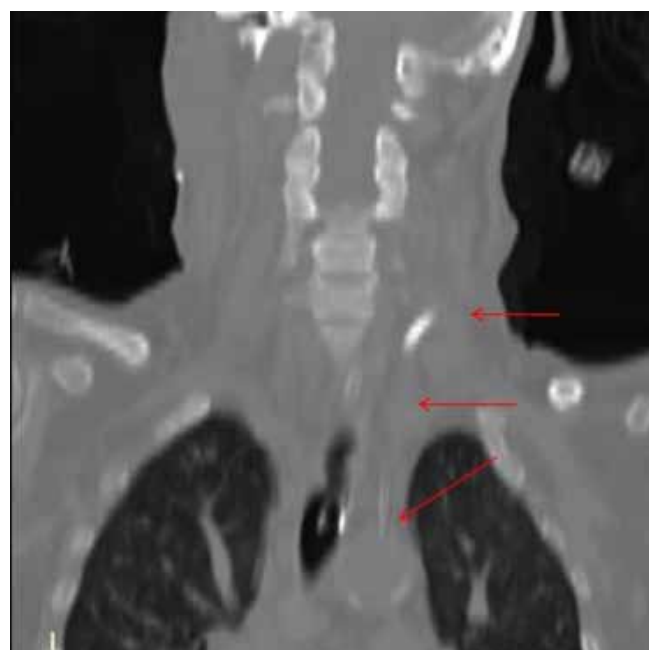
Coronal section CT neck showing dialysis catheter can be seen approaching aorta (red arrows).
